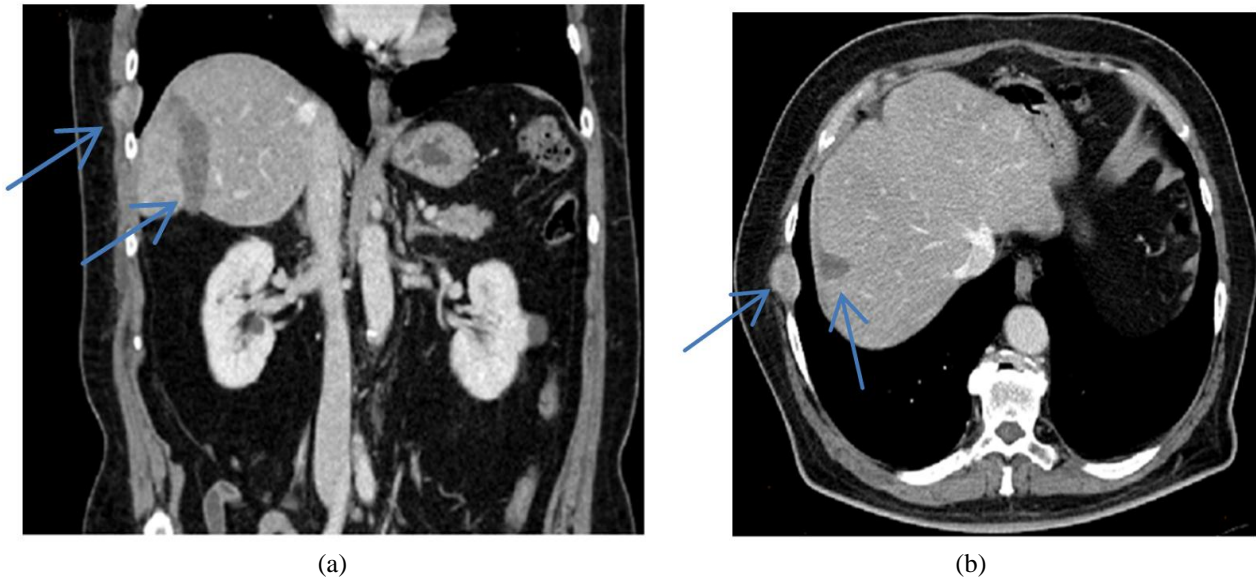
(a) Coronal CT scan shows solid lesion between ninth and tenth ribs in right chest wall. Results of previous hepatic surgery are also evident. (b) Axial CT scan shows solid lesion between ninth and tenth ribs in right chest wall. Results of previous hepatic surgery are also evident.
